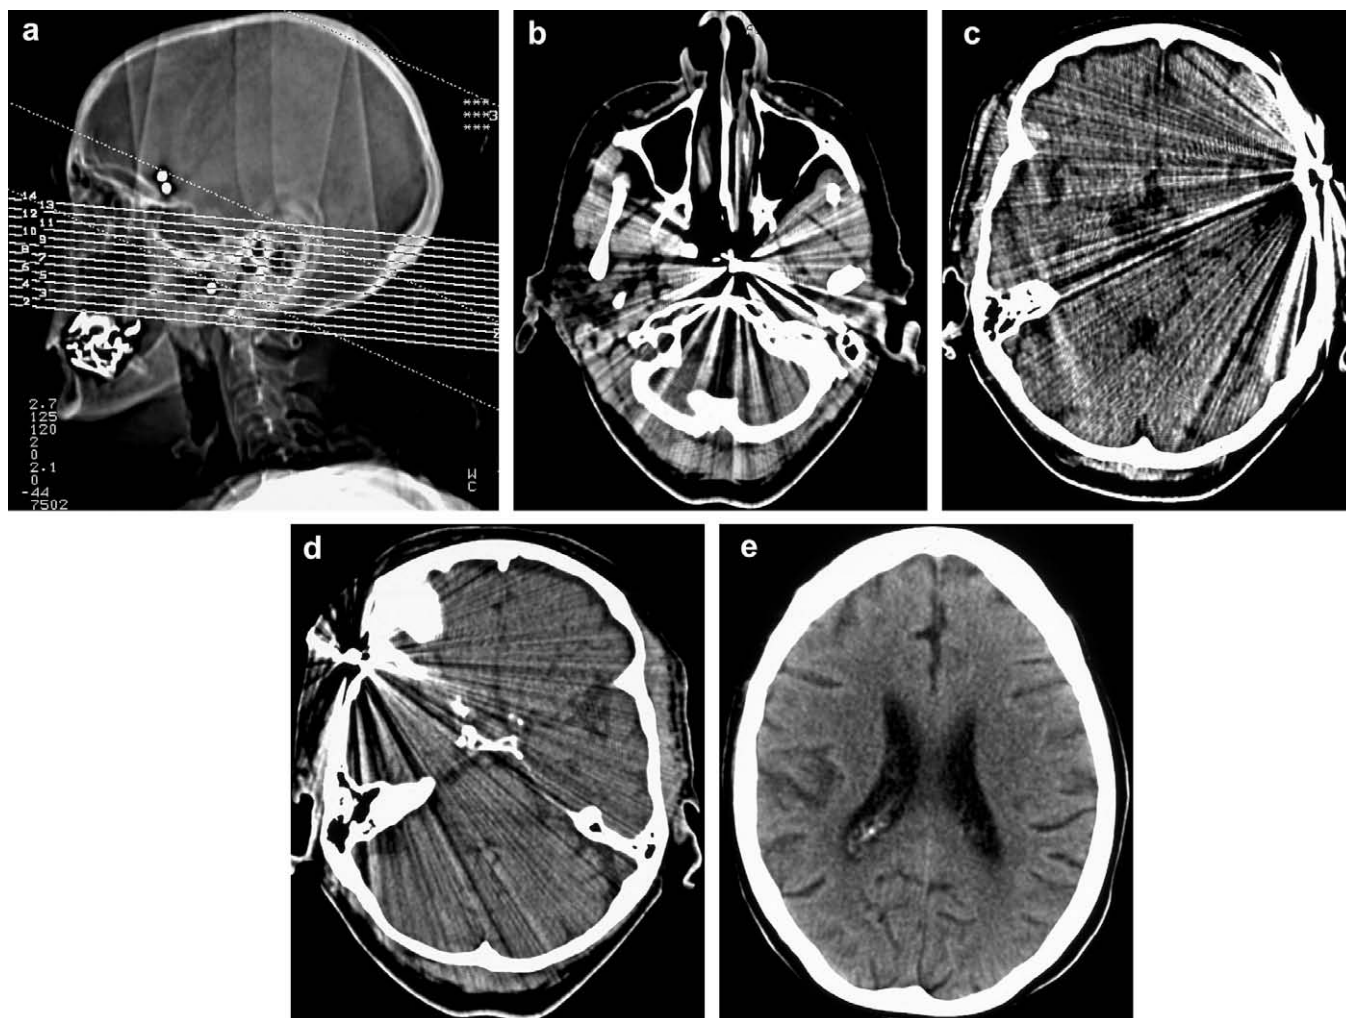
Emergency imaging studies of a 74 year old male patient after attempted suicide with a shotgun. (a) lateral X-ray demonstrating two bullets in the temporal bone and one in the hard palate. (b–d) axial CCT scans with metal artifacts at the described locations. (e) axial CCT scan at the level of the ventricles excluding a brain injury or bullet penetration.
